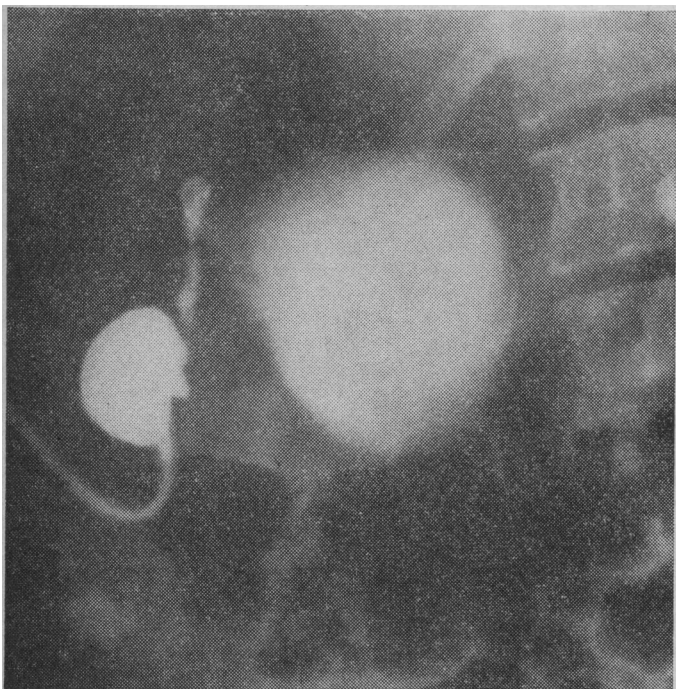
X-ray film showing choledochus cyst and collapsed gall bladder.
